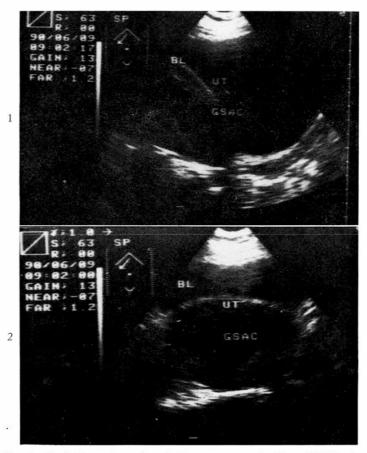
Longitudinal ultrasonic section of the empty gestational sac (GS) in the uterus (10th week of amenorrhea).
